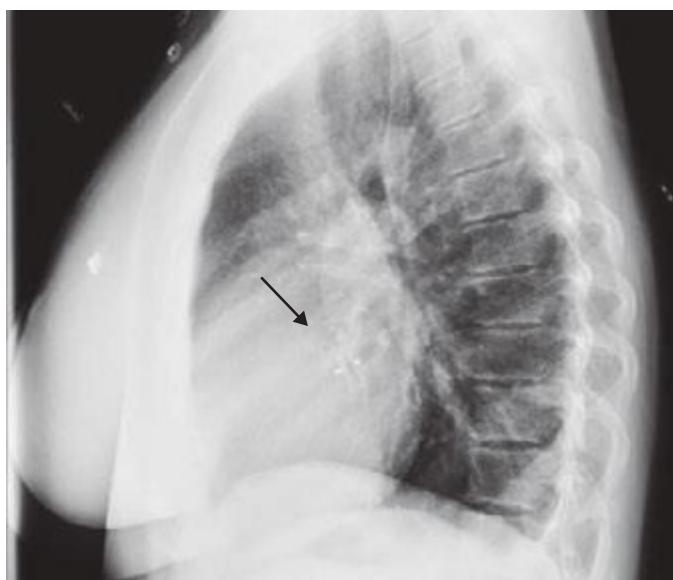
21 Postprocedure lateral chest x-ray showing the Amplatzer® septal occluder in place.
